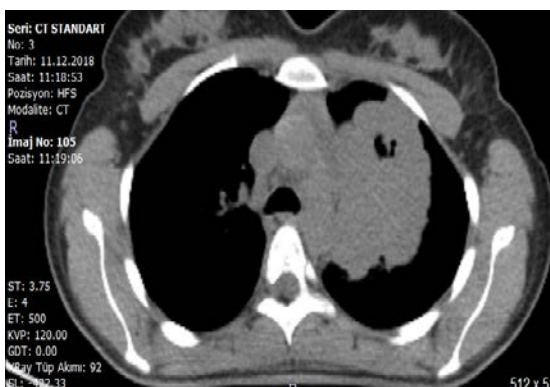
A lesion in the upper lobe of the left lung lying to paramediastinal area (thorax CT).
